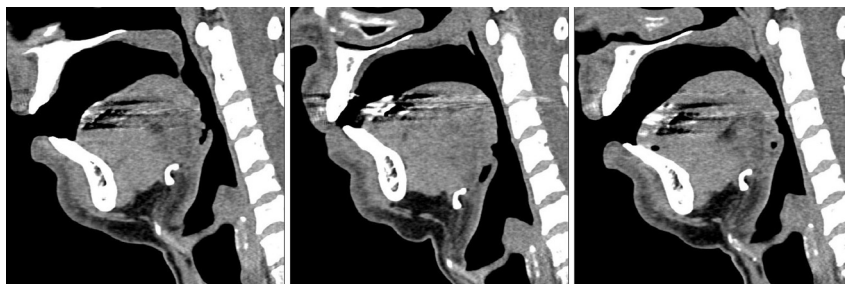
Midsagittal images of the vocal tract. Before straw (left), during straw (middle), and after straw (right). Likewise as in Figure 2, the two most evident changes are the higher velum and the lower laryngeal position in both during and after straw phonations. Additionally, the hypopharynx is much wider during straw phonation. The straw is not visible due to the fact that it is made of a very thin walled and a very soft material, which is out of the CT scan possibilities.
